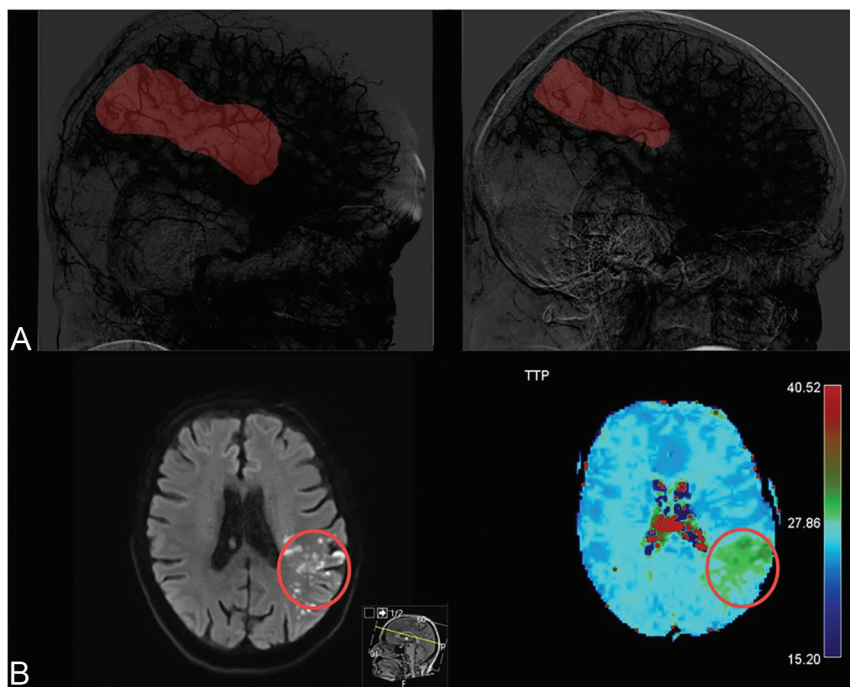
A patient with a persistent perfusion deficit after receiving IA urokinase. *A*, The first DSA shows left-sided occlusions of the M2 MCA segment (*left panel*). The last DSA series after MT shows that the patient has achieved reperfusion of 50% of the initial target territory (eTICI 2b50) (*right panel*). DSA runs are shown with high contrast in order to emphasize the capillary phase deficits. Areas in red show nonperfused territory. *B*, Follow-up MR imaging performed 24 hours after the end of the intervention. DWI shows a newly developed distal infarct (*left panel*). Postprocessed perfusion imaging shows a persistent perfusion deficit that directly corresponds to the nonperfused territory from the final DSA series (*right panel*).
